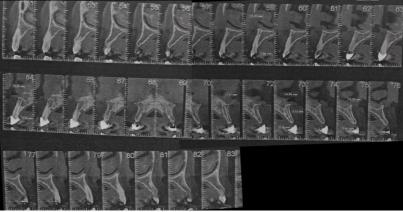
Cone-Beam Computed Tomography Scan (CBCT)
